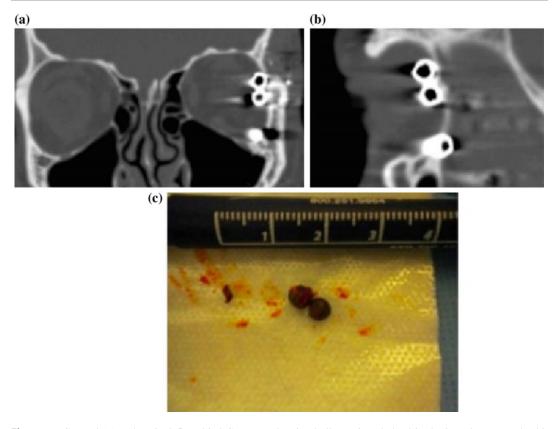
Coronal (a) and sagittal (b) orbital CT scans showing bullet casings lodged in the lateral extraconal orbit causing fracture of the lateral orbital wall. The foreign bodies were removed via orbitotomy (c)
